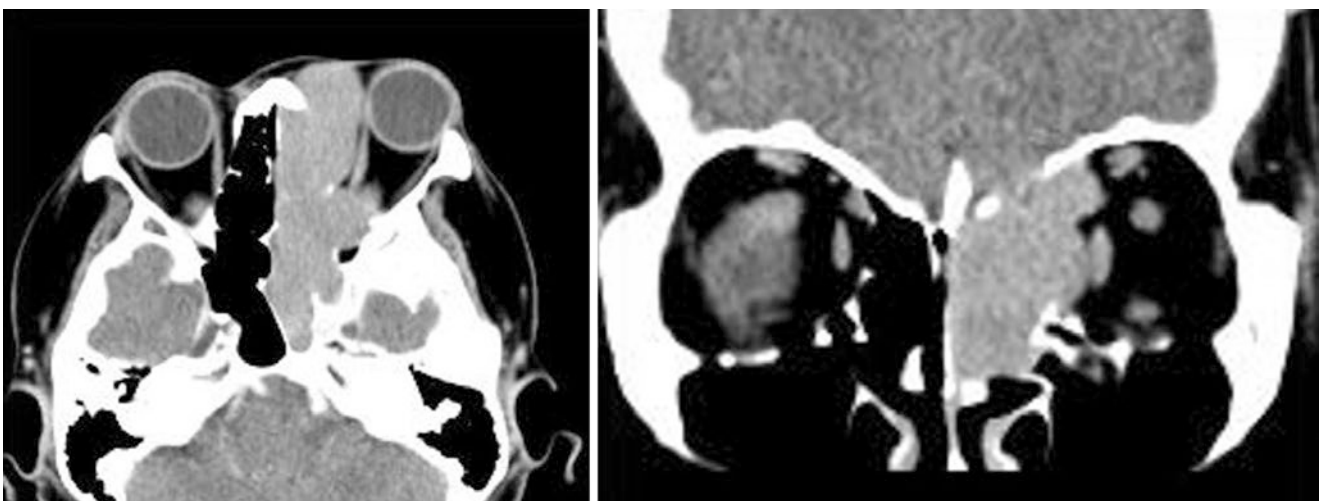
Contrast-enhanced axial and coronal CT scans showing smooth, lobulated, expansile mass centred on the left frontal, ethmoid and sphenoid sinuses, with intracranial, nasal cavity and extraconal
